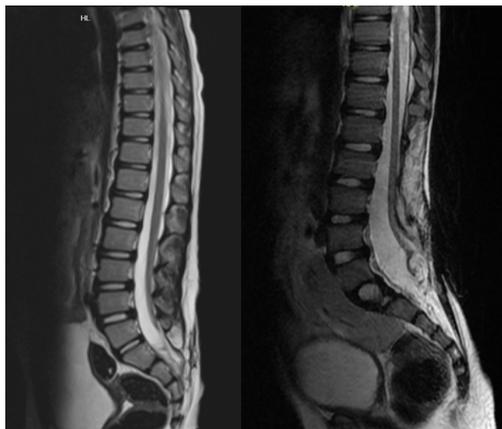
The image is taken from own clinical archive. MRI image of a meningocele patient is shown.
